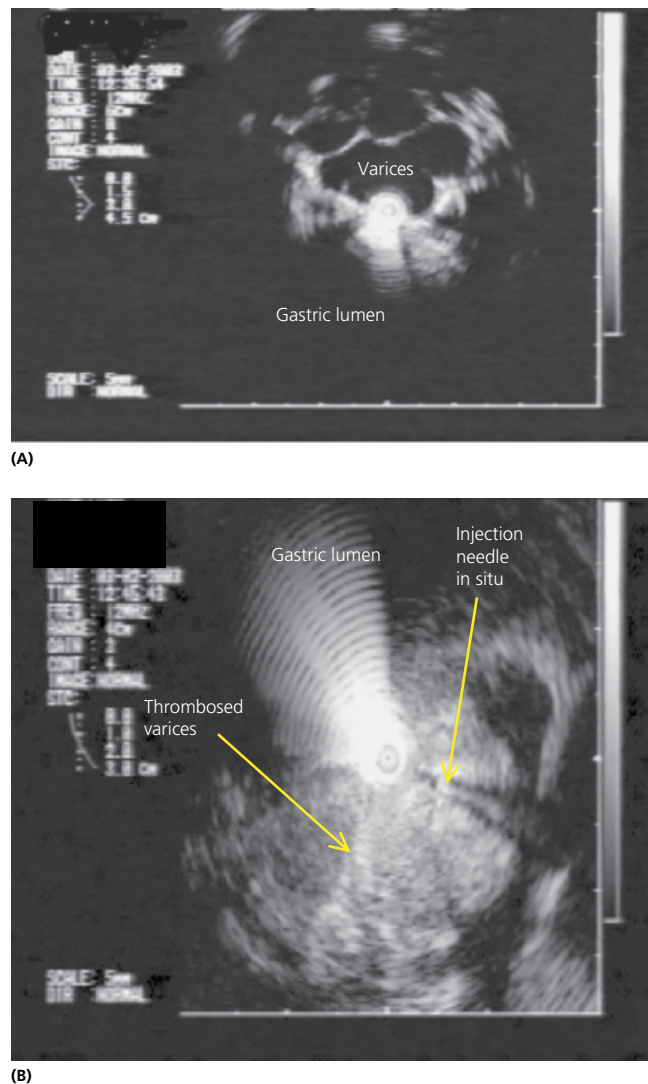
Endoscopic ultrasound is a useful way of detecting submucosal varices (A) before and (B) after injection with thrombin.
